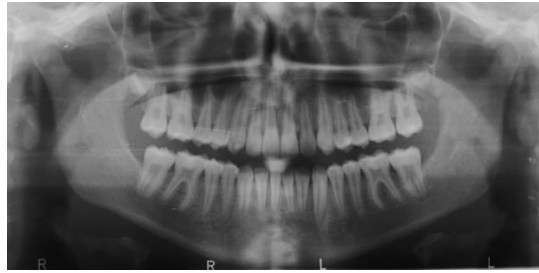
Orthopantomography records during Additional Aligner phase.
